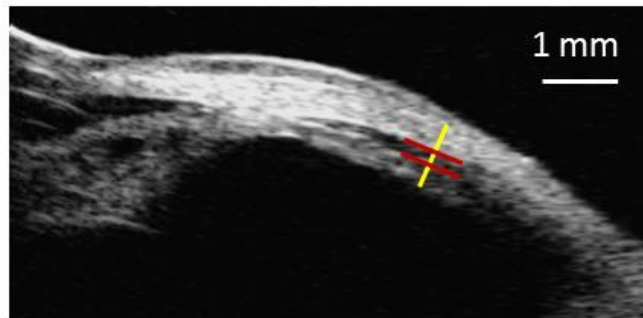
Calculation of SCS thickness in ultrasound B scans. A line segment perpendicular to the sclera and choroid, from the outer sclera to the inner retina, is found. The conjunctiva is excluded from the measurement. The tissue thickness is found and subtracted out, resulting in the SCS thickness.
